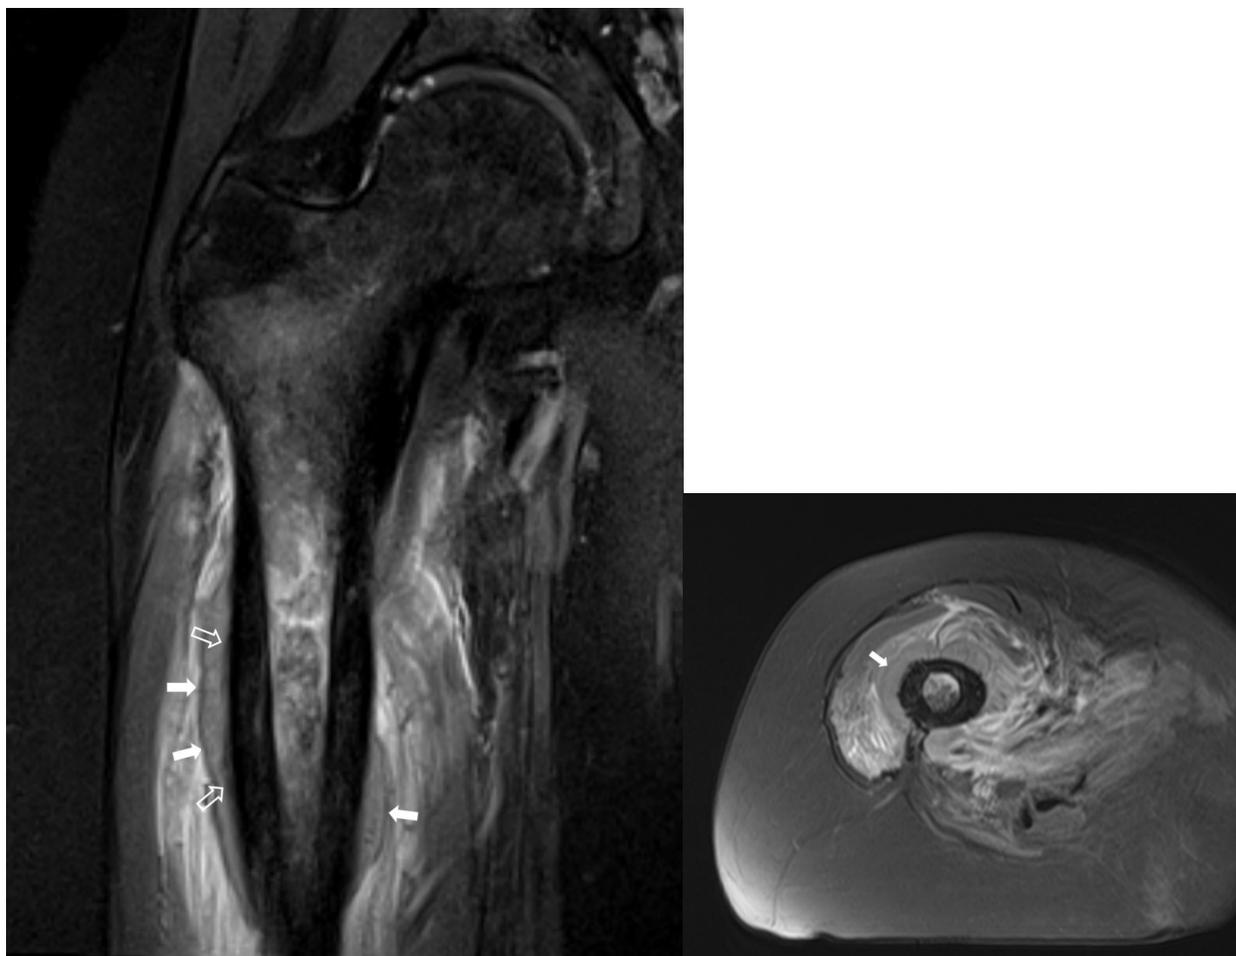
A and B. Coronal and axial fat suppressed T2 weighted MRI. Significant marrow edema centered within the marrow extending from the diaphysis into the intertrochanteric region of the femur. Serpiginous marrow appearance is suggestive of bone infarct. Intermediate signal intense soft tissue mass with thin hypointense margin (solid arrows) is observed concentrically adjacent to the marrow edema, consistent with lifted periosteum and underlying tumor mass. Thin interrupted linear hypointensity is noted closer to the cortical surface with appearance of Codman's triangles (open arrows), consistent with laminated periosteal reaction that has been blown through by aggressive tumor extension.
